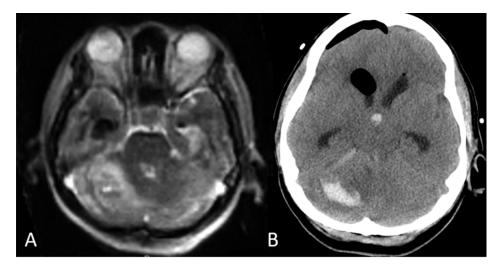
51 year old female patient who presented to hospital with acute subarachnoid hemorrhage and hydrocephalus due to anterior communicating artery aneurysm rupture. pMRI performed after EVD insertion (A, T2WI) showed new hemorrhage in the right cerebellum likely representing remote cerebellar hemorrhage, confirmed on subsequent CT head performed later on the same day (B).
